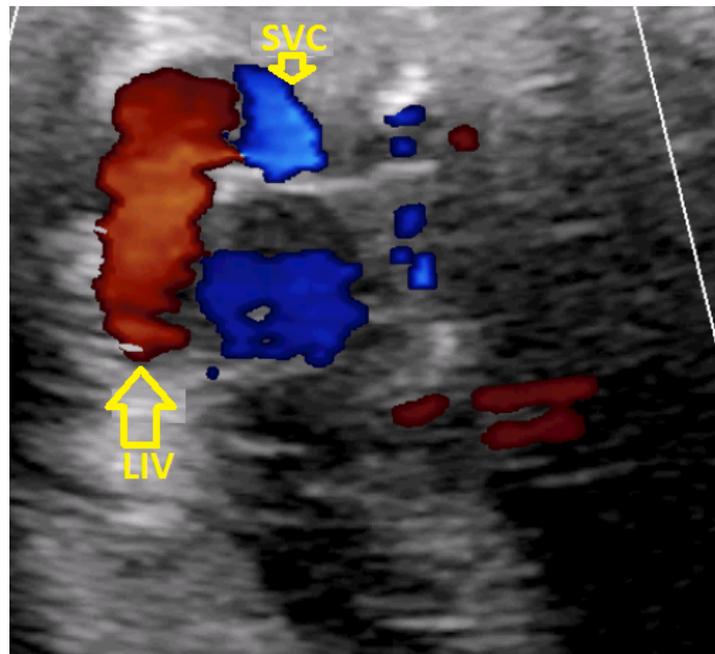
Color doppler of axial view Showing high flow and dilated Left Innominate Vein (LIV) and Superior Vena Cava (SVC).
